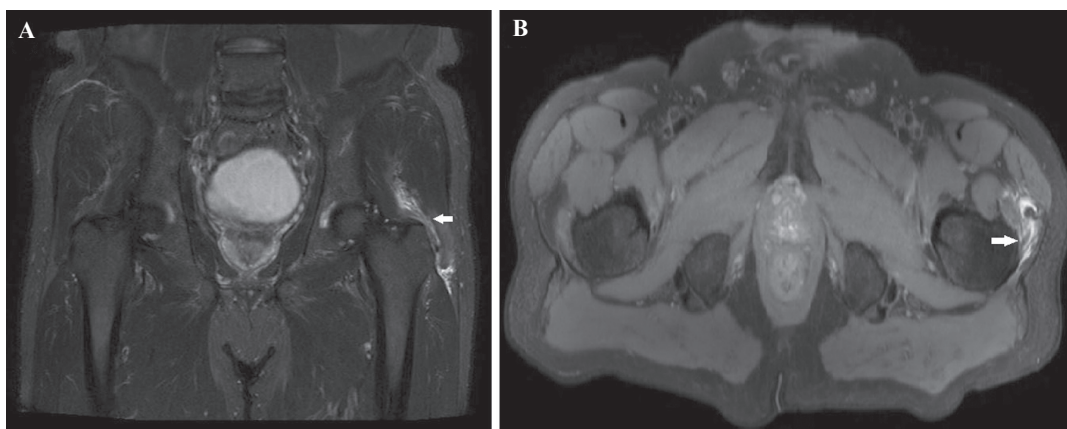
MRI bilateral hip region: Coronal image (A: short inversion time inversion recovery sequence) and axial image (B: proton density fat-sat sequence) showed mild-to-moderate hyperintensity involving tendons of the left gluteus medius and gluteus minimus near the insertion site at greater trochanter (marked by arrows) suggestive of tendinitis
